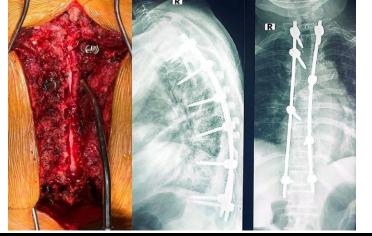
Intraoperative image and post-operative x-rays.
